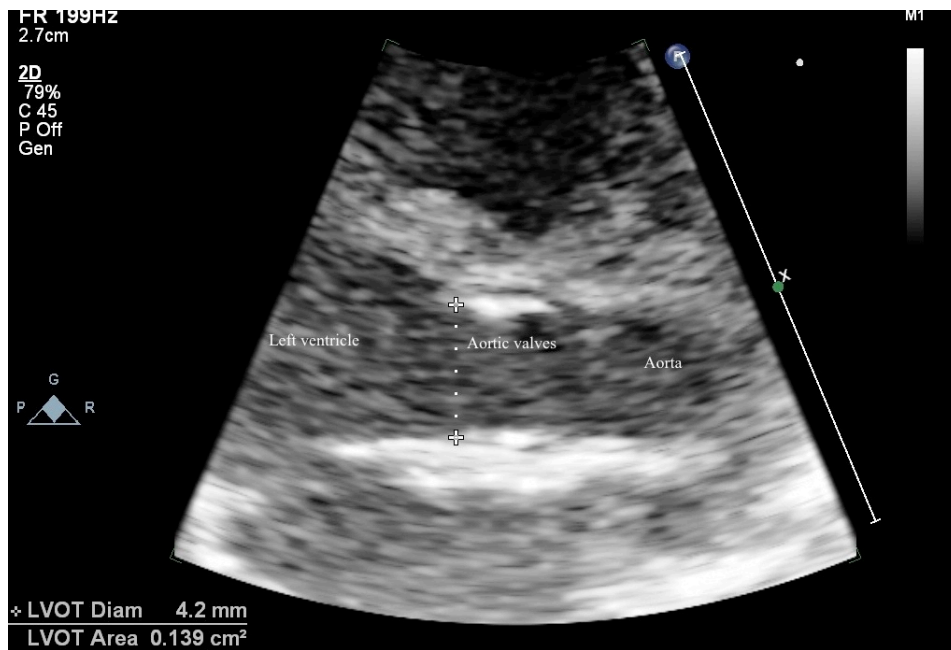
Cross-sectional view of the left ventricular out flow tract. Using the long axis parasternal view, the aortic valve diameter measurements are taken from hinges of the aortic valve.
